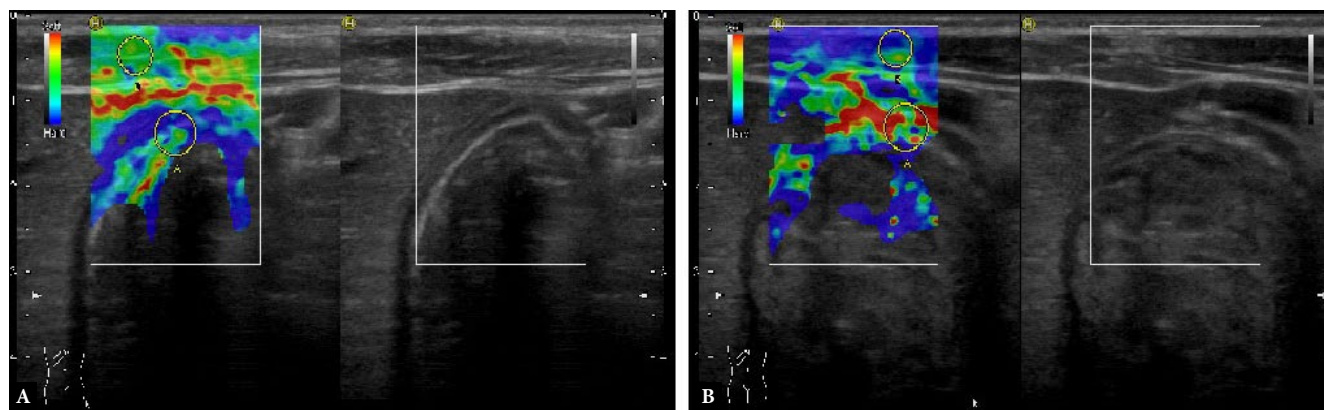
A. A seven year-old boy suffering from *H. pylori* infection underwent strain elastography examination. The strain values obtained from the thickened gastric wall were compared with the stomach surface of the neighboring muscle tissue which was accepted normal. B. Strain value measurement in a healthy 5-year-old volunteer boy. After clinical examination, the patient's gastric wall was scanned using B-mode sonography and after no thickening has been shown, the color map was obtained and the region of interest was measured. The value was 0.24, which corresponded to normal limits in the healthy volunteer group
